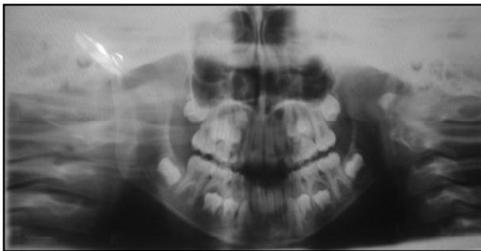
Orthopantomogram with patient preparation errors: failure to remove the earrings (which cause "ghost" images of them in the maxillary second molars areas), chin tipped up (vertical error) and head movement during exposure (personal casuistry)
